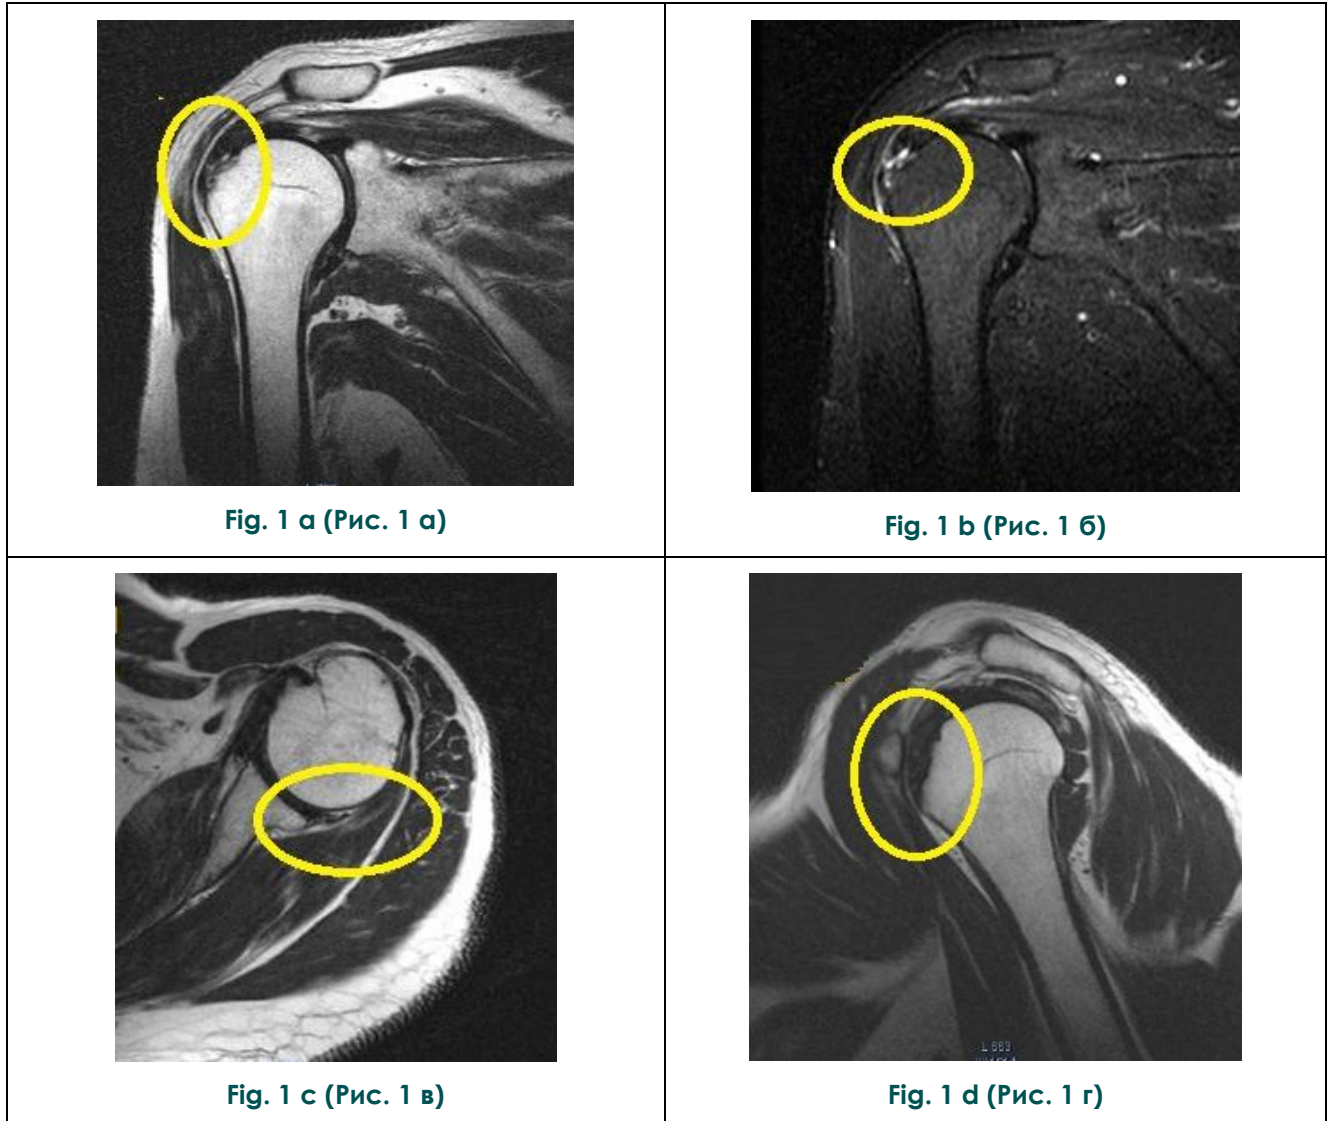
MRI of right shoulder joint.
